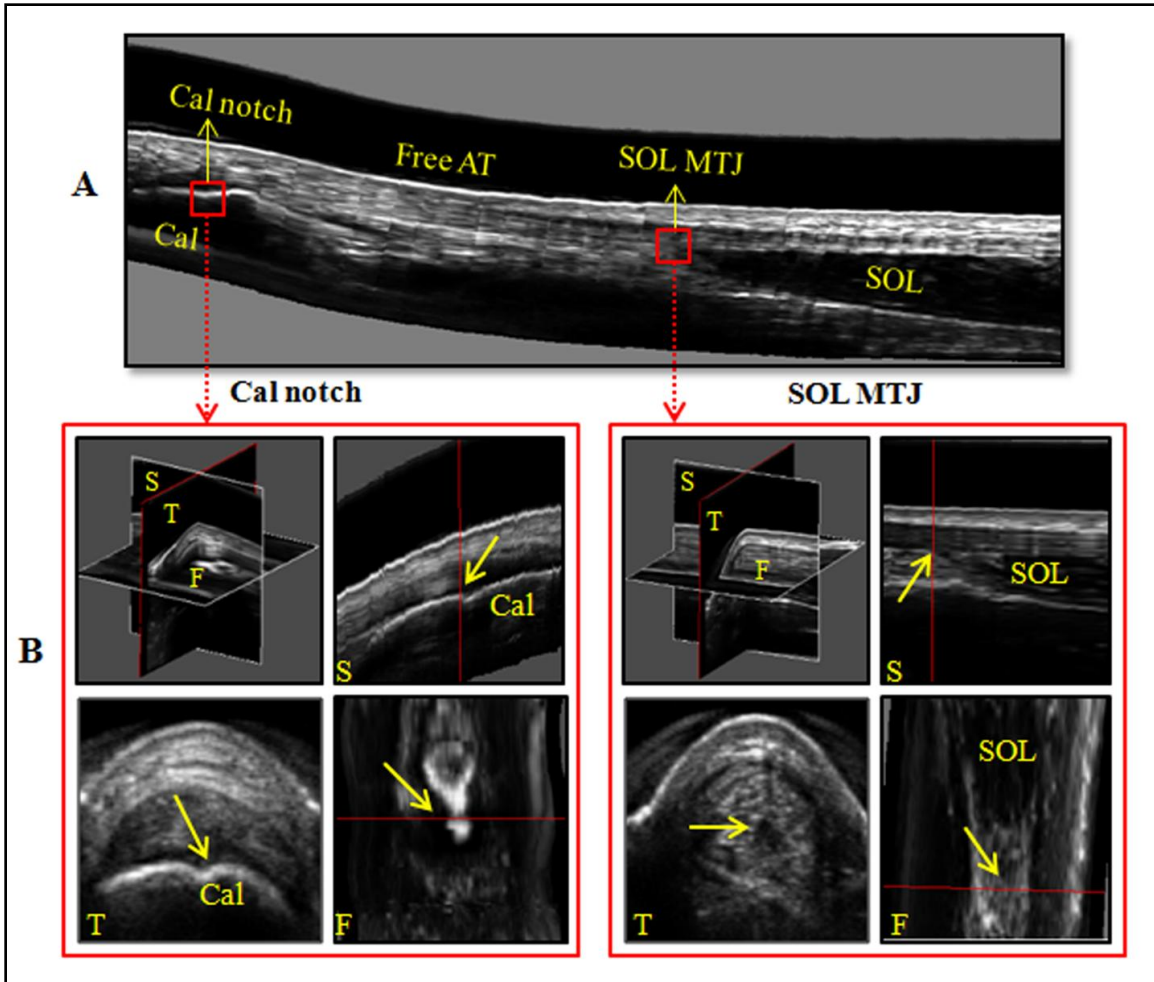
(A) Sagittal plane re-slices of a reconstructed three-dimensional (3D) ultrasound image of the free Achilles tendon (AT). Two anatomical landmarks [calcaneal (Cal) notch, and soleus muscle-tendon junction (SOL MTJ)] were segmented on 3D AT images for calculation of AT length. (B) The exact 3D anatomical location of each landmark was determined using sagittal (S), frontal (F), and transverse (T) image planes.
